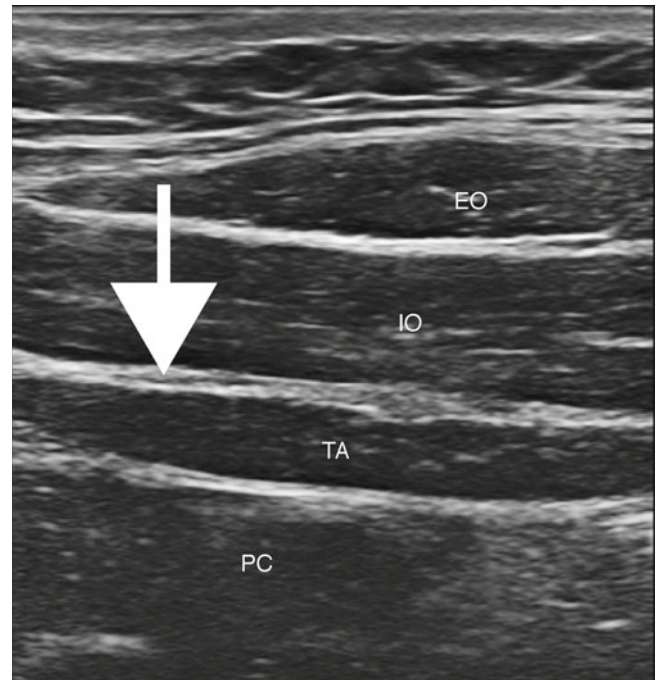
Identification of muscle layers under ultrasound. External oblique (*EO*), internal oblique (*IO*), transversus abdominis (*TA*), peritoneal cavity (*PC*), transversus abdominis plane (*bold white arrow*)
